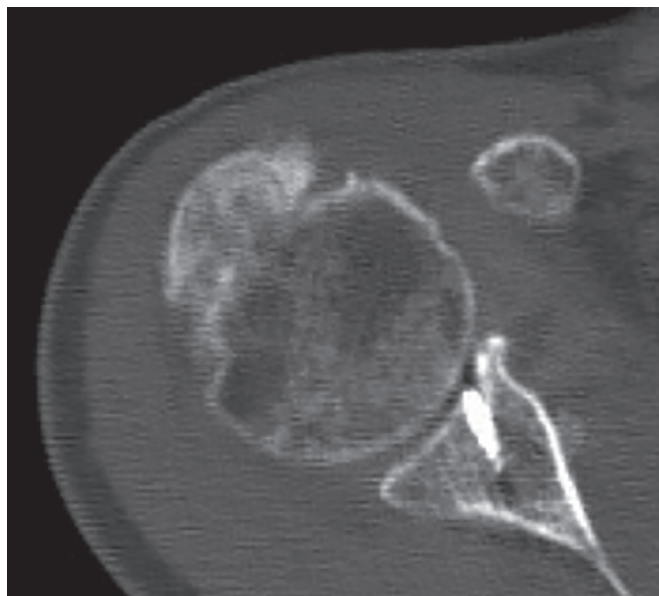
A patient with concomitant fractures of the greater tuberosity and glenoid. 2 months after surgery, follow-up CT scan showed good healing status of the fractures.
